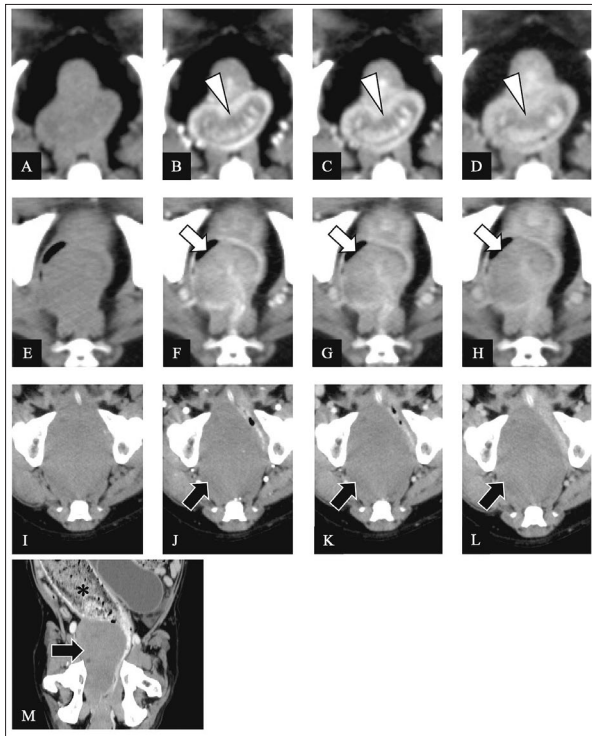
Representative CT images of rectal neoplasms forming a mass lesion. CT images of inflammatory polyps in pre-contrast (A), arterial-phase post-contrast (B), portal-phase post-contrast (C), and equilibrium-phase post-contrast (D) images; CT images of adenocarcinoma in pre-contrast (E), arterial-phase post-contrast (F), portal-phase post-contrast (G), and equilibrium-phase post-contrast (H) images; and CT images of leiomyomas in pre-contrast (I), arterial-phase post-contrast (J), portal-phase post-contrast (K), equilibrium-phase post-contrast (L), and a reformatted dorsal plane (M) images. The inflammatory polyps show radial enhancement (arrowhead). The adenocarcinomas show slightly less enhancement than the mucosa (arrow). The leiomyomas show homogeneous and less enhancement outside the mucosa (black arrow) with obstruction. *: Dilatation of the proximal colon.
